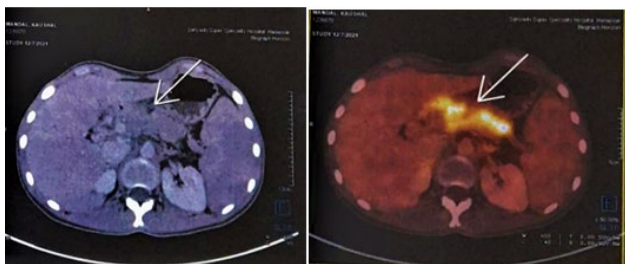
PET CT Hypermetabolic SOL pancreas
